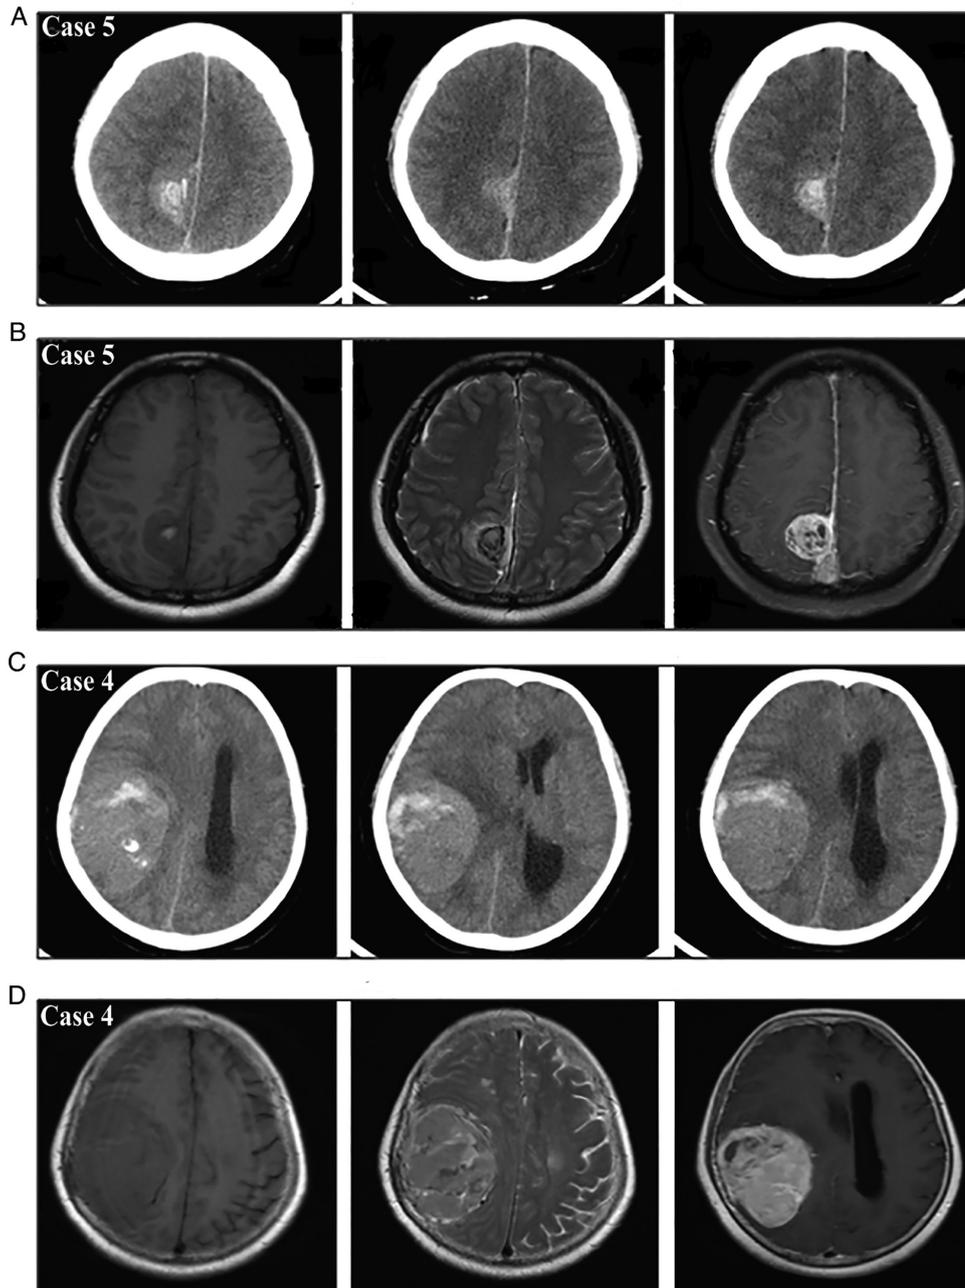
Radiological findings for (A and B) representative case 5 and (C and D) case 4 with solitary intratumoral hemorrhage. Preoperative brain computed tomography showing (A) a round iso-dense mass in the right parasagittal area of case 5 and (C) a large mass with high density in the right parietal region of case 4, with multi-foci of hyperdensity suggestive of intratumoral hemorrhage. Brain magnetic resonance imaging revealing (B) a dural-based mass in the right parasagittal area of case 5 and (D) a dural-based mass in the right parietal region of case 4, with heterogeneous enhancement on contrast. The peripheral area of the two masses was significantly enhanced, and the central non-enhancing area suggested acute intratumoral bleeding.
